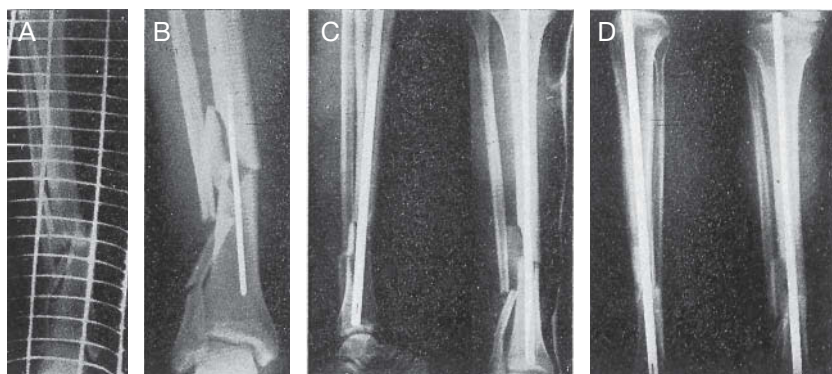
J.L.S. Open tibial and talar fracture with a third fragment (this patient had an associated ipsilateral femoral fracture). A: Preoperative x-rays. B: Perioperative x-ray showing the guide in place. C: Radiographic image at 2 months. D: View at 7 months, final result.
